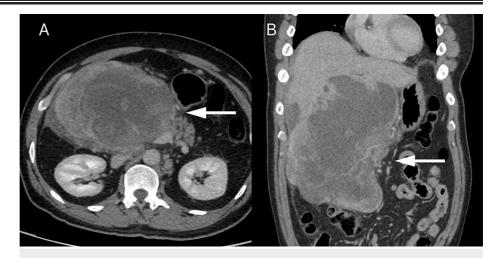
Contrast-enhanced CT images in the portal venous phase
